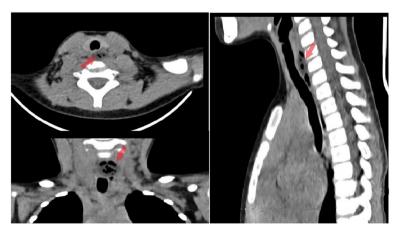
Foreign body in the cervical esophagus on thorax CT
